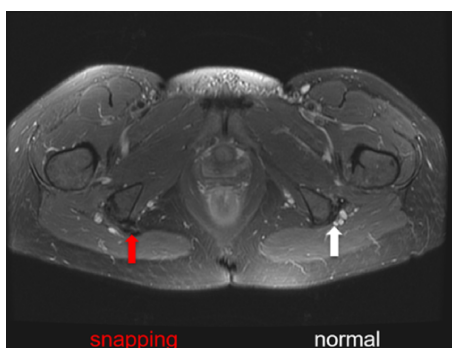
Magnetic resonance image demonstrating tear/disruption of the injured snapping proximal hamstring tendon (red arrow) compared with the uninjured contralateral tendon (white arrow).
